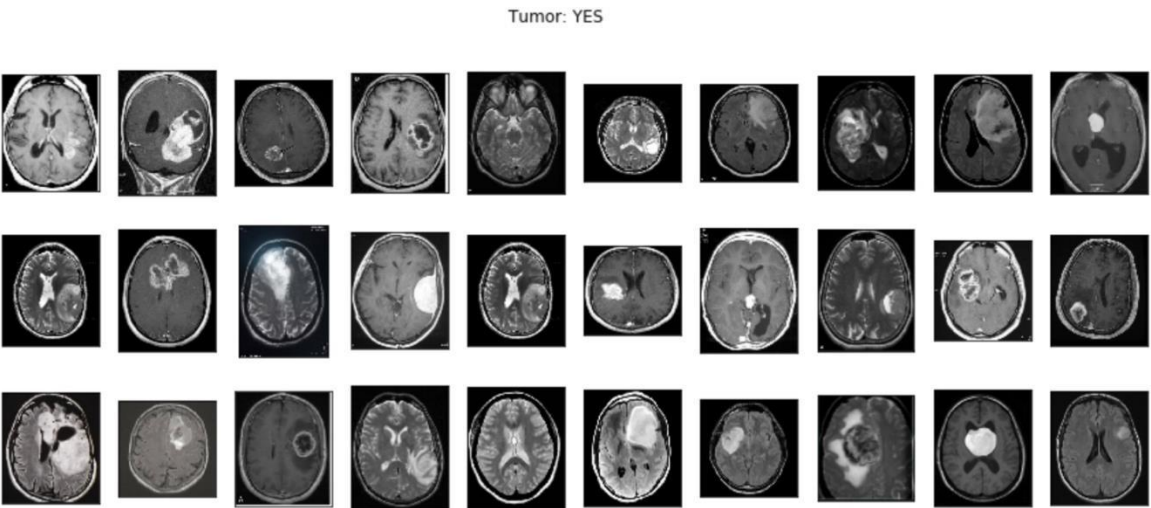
MRI of Brain with Tumor
